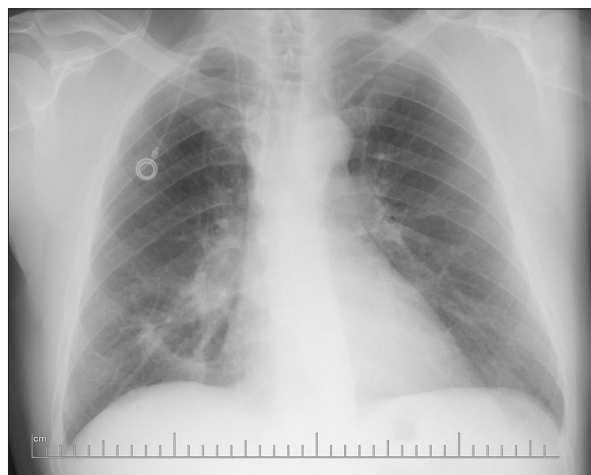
Chest X-ray showing right hilar enlargement
